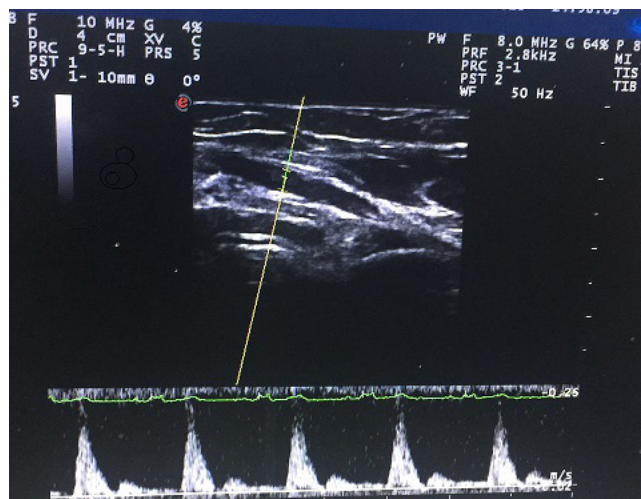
Flow and diameter of axillary artery by Pulse-Wave Doppler US.
